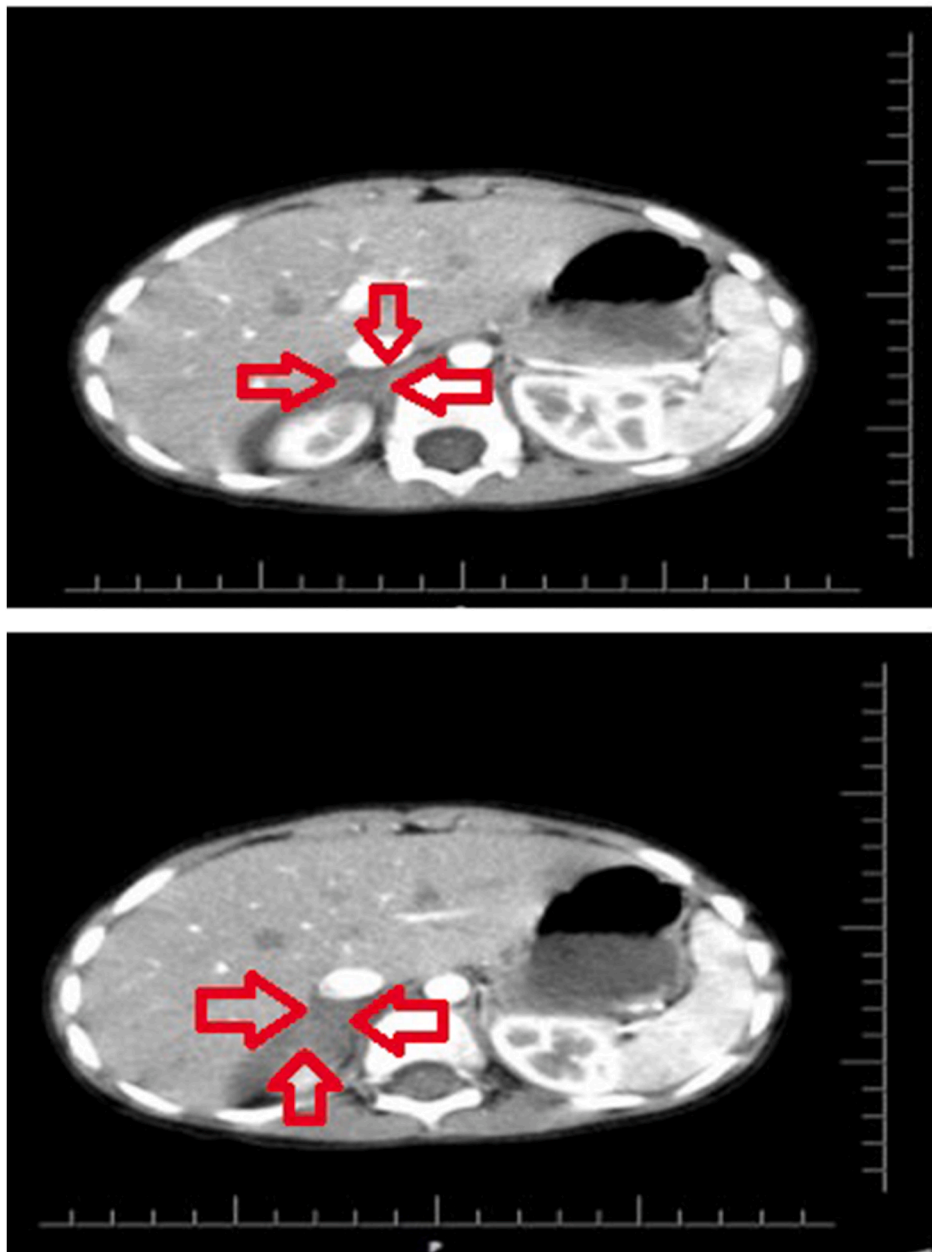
Axial view of enhanced abdominal CT scan.
